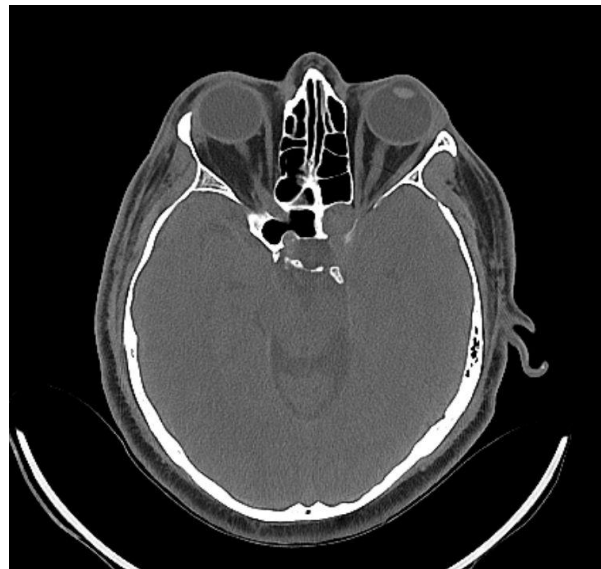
Pre-operative CT paranasal sinus (axial bone window) demonstrating soft-tissue density filling the sphenoid sinus with associated bony erosion of the sphenoid sinus wall and narrowing of the left optic canal.
